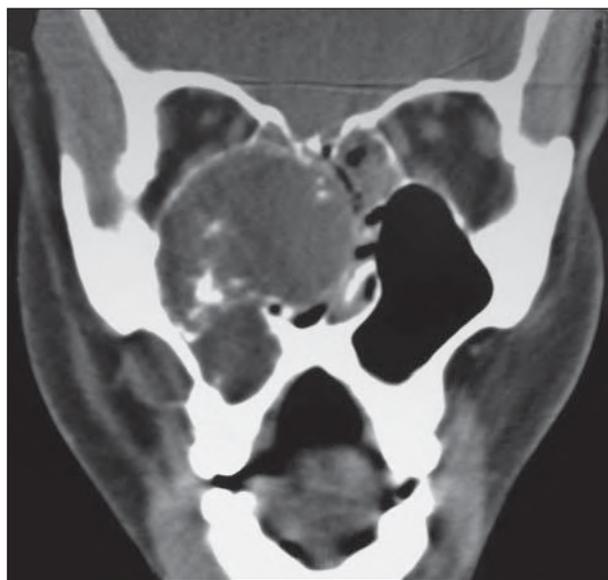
Preoperative coronal computed tomographic scan in a patient with massive odontogenic neoplasm of the right maxilla with involvement of the orbital floor.
